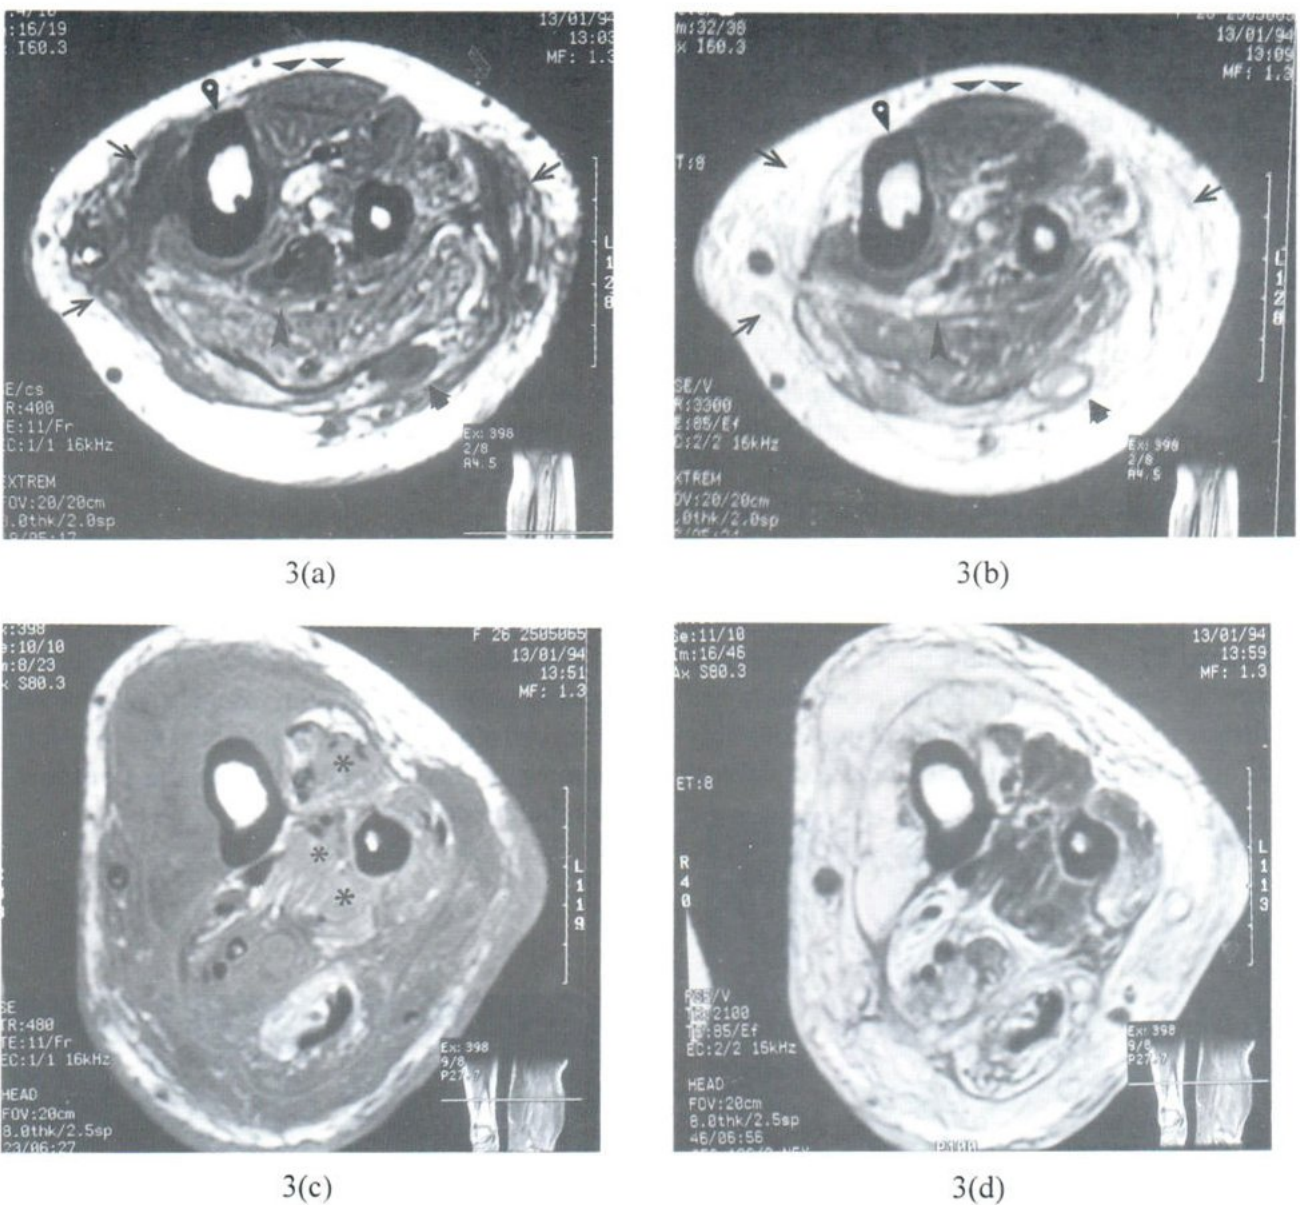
(a) T1-weighted (400/11 [TR/TE]) and (b) gradient recalled echo (GRE)(600/20; flip angle, 15 degrees) axial MR images through the level of middle third of tibia reveals infiltrative lesion involving both subcutaneous fat and muscles (arrows). Its signal intensity is lower than normal muscles (broad arrowheads) on T1W1 and turning bright on GRE image. A well-defined, focal neurofibroma is observed within lateral gastrocnemius muscle (short thick arrow) and having internal cystic component. Another focal plexiform lesion is noted surrounding the posterior tibial neurovascular bundle (arrowhead). Abnormal thickening of bony cortex is also observed (round arrowhead.) (c) T1- weighted (480/11) and (d) GRE (680/20; flip angle, 15 degrees) axial MR images 20 mm below a) and b) exhibit more extensive lesion. On T1WI (c) the signal intensity of the lesion is lower than normal muscles (asterisks). The low-SI linear or serpentine structure seen within the lesions on GRE image represent muscle bundles and fascia separated by the tumor.
